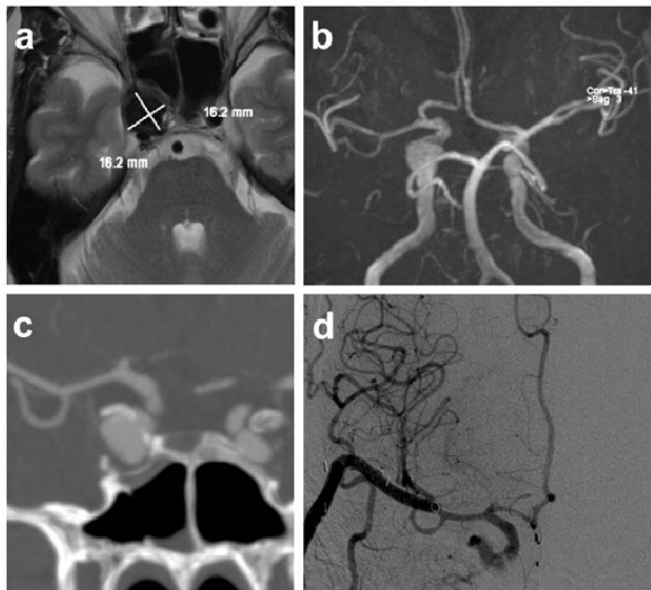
Partial trapping (inflow occlusion) with EC-IC (Elana) bypass. Pre-operative axial MRI (a), MRA (b) and CTA (c) showing an aneurysm of the right intracavernous ICA. The patient underwent treatment consisting of: 1) EC-IC high flow bypass performed by interposition of a saphenous vein graft between the external carotid artery and the MCA (M2 segment); 2) subsequent proximal occlusion of the cervical internal carotid artery in the neck just distal to the common carotid artery bifurcation. Postoperative DSA (figure d) showed patency of the EC-IC bypass and partial aneurysmal thrombosis. Note that the intracranial anastomosis has been made by the application of the Excimer- Laser Assisted Non Occlusive Anastomosis (ELANA) technique, in order to avoid temporary occlusion of a proximal intracranial recipient (namely the supraclinoidal ICA or the MCA) and subsequent risk of cerebral ischemia.
